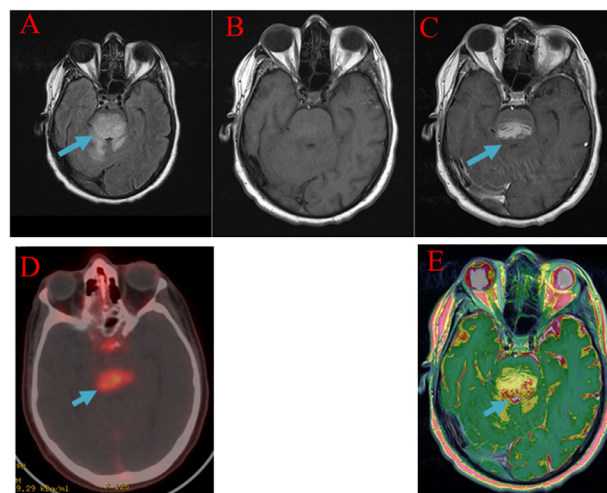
Axial images at the level of pons: Flair (A), T1 WI MR pre (B), and post contrast (C), fused ^{18}F Choline PET/CT (D) and fused ^{18}F Choline MR (E) are showing hyperintensity lesion blue arrows in (A) with contrast enhancement and choline activities.
